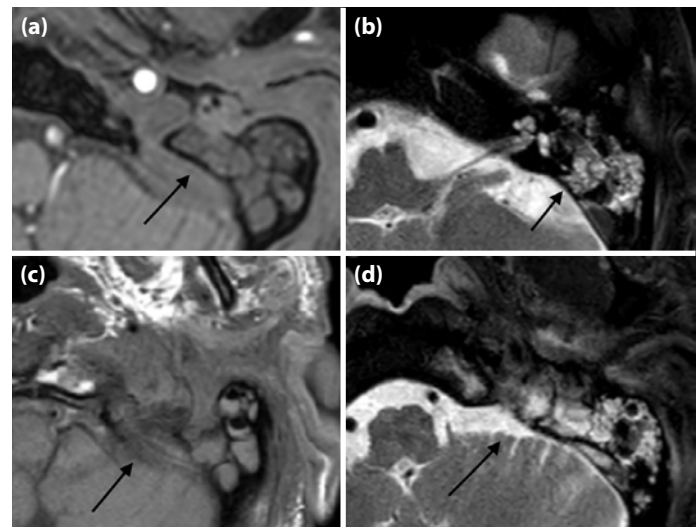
Pretreatment axial T1 (a), T2 (b) and posttreatment axial T1 (c), T2 (d) weighted magnetic resonance images of Case 1. White arrows indicate inflammation in the clivus and petrous apex, in addition to the mastoid air cells.
